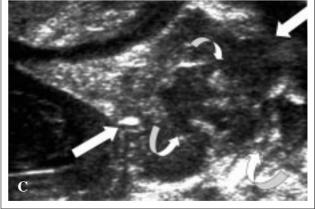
Intraventricular massive flooding. Through the anterior fontanelle, in midsagittal (A) and posterior coronal sonograms (B): poor definition of cerebellar borders (straight arrows). With linear high frequency transducer (C), through the mastoid fontanelle, high cerebellar definition (straight arrows). Fine clots are observed within the fourth ventricle, widening of the lateral recesses of the fourth ventricle (curved arrows).
